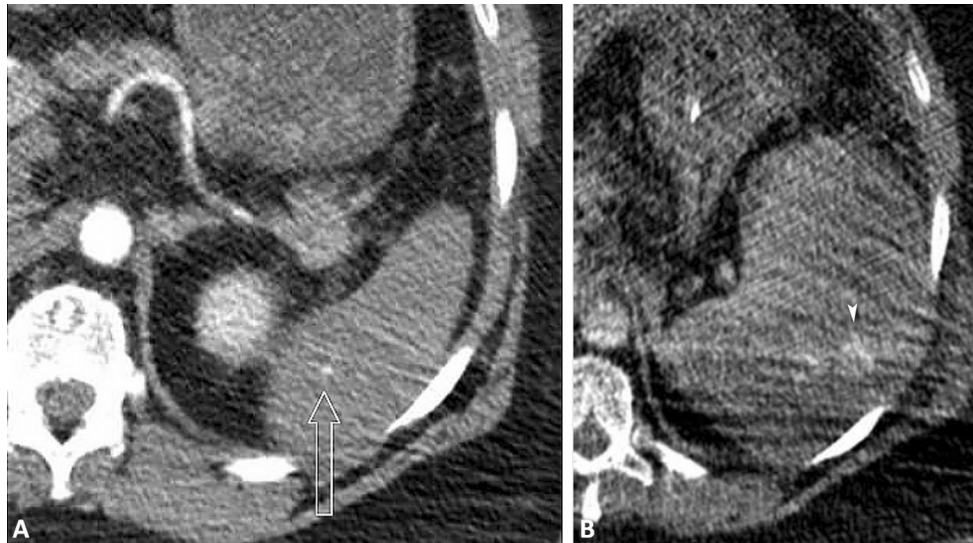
Failure of NOM. A Female, 58 years, accidental fall. CT at admission shows a grade II splenic injury with a millimetric pseudoaneurysm (open arrow). B 6 days after admission CT shows
